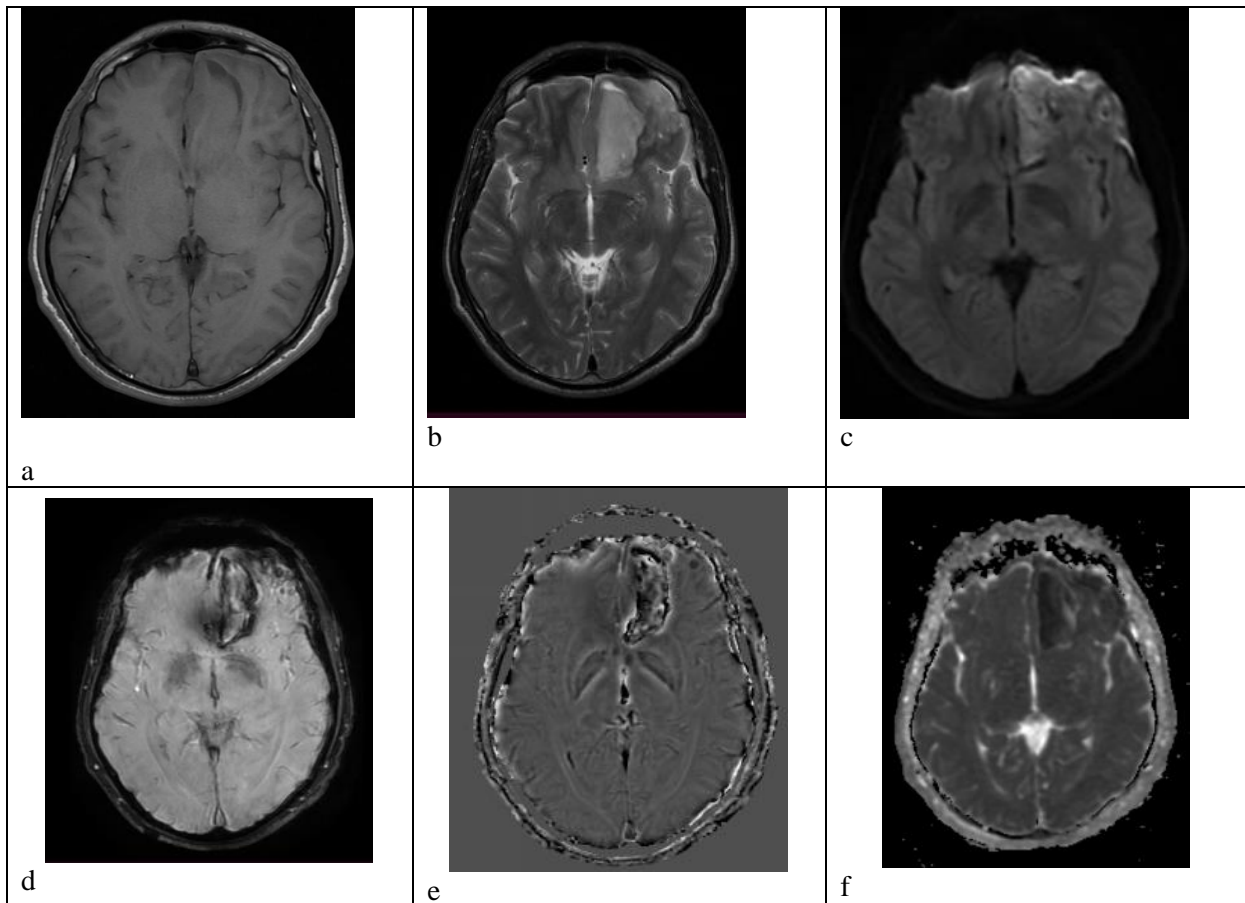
Demonstrates *hyperacute* left frontal parasagittal hematoma with image (a) points to T1 with isointense signals, (b) T2 WI image with bright signals (c) bright signal at DWI with low rim as well (f) the corresponding low signals at ADC map, (d) the SWI images with bright center & low signals and blooming at margin while (e) the corresponding phase contrast image.
